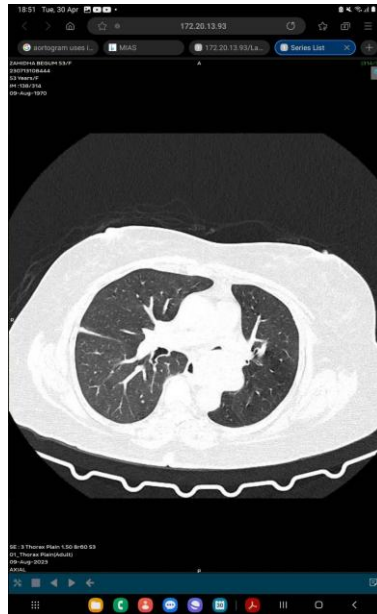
Lung-window CT image showing airway narrowing related to the mediastinal cyst.
